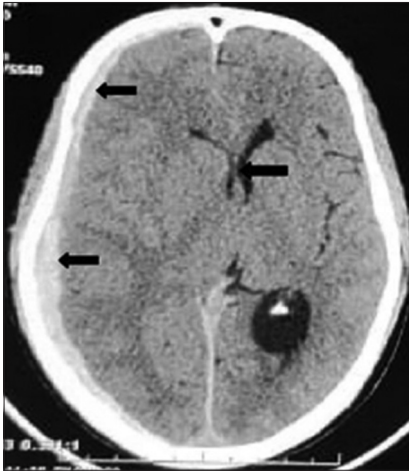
Computed tomography brain head axial image showing large right frontoparietal subdural hemorrhage with shift of midline toward the left and dilatation of contralateral lateral ventricle
